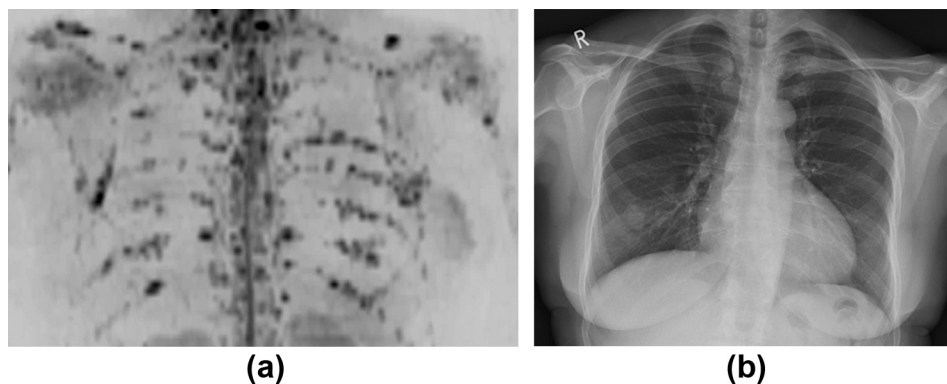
Images of the chest in a 65-year-old female patient with non-secretory myeloma shown by (a) inverted greyscale $b = 900$ s/mm² DWI images and (b) chest radiograph. Numerous discrete focal lesions are visualized in the ribs on the DWI, which are not easily seen on the chest radiograph.
